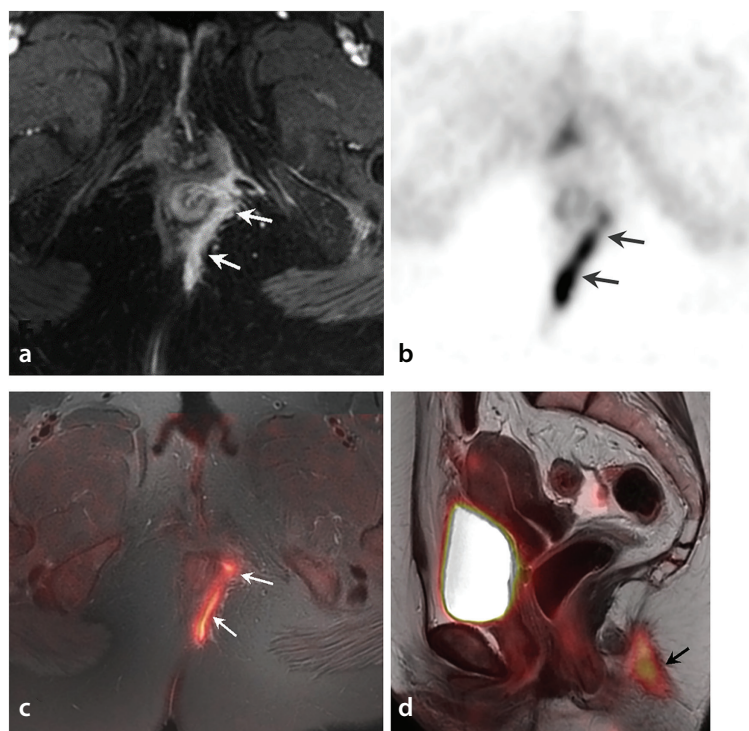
Transsphincteric perianal fistula. The axial contrast-enhanced fat-suppressed T1-weighted image (a) shows a fistula tract (arrows), which begins at the 1 o'clock position and curves posteriorly, penetrating the external anal sphincter. The axial positron emission tomography (PET) (b) and axial fused PET/magnetic resonance images (MRI) (c) reveal intense fluorodeoxyglucose accumulation along the tract (arrows). The sagittal fused PET/MRI (d) shows pathological uptake posterior to the external anal sphincter (arrow).
